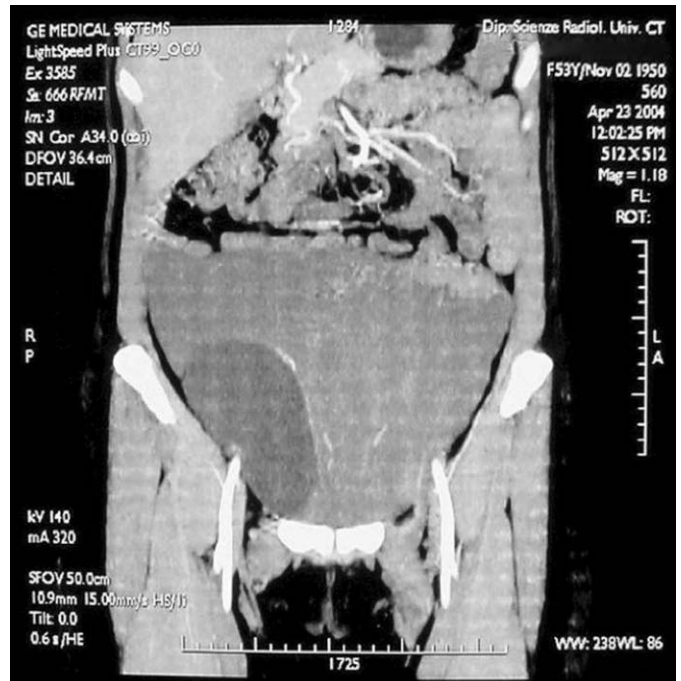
Preoperative CT scan.
